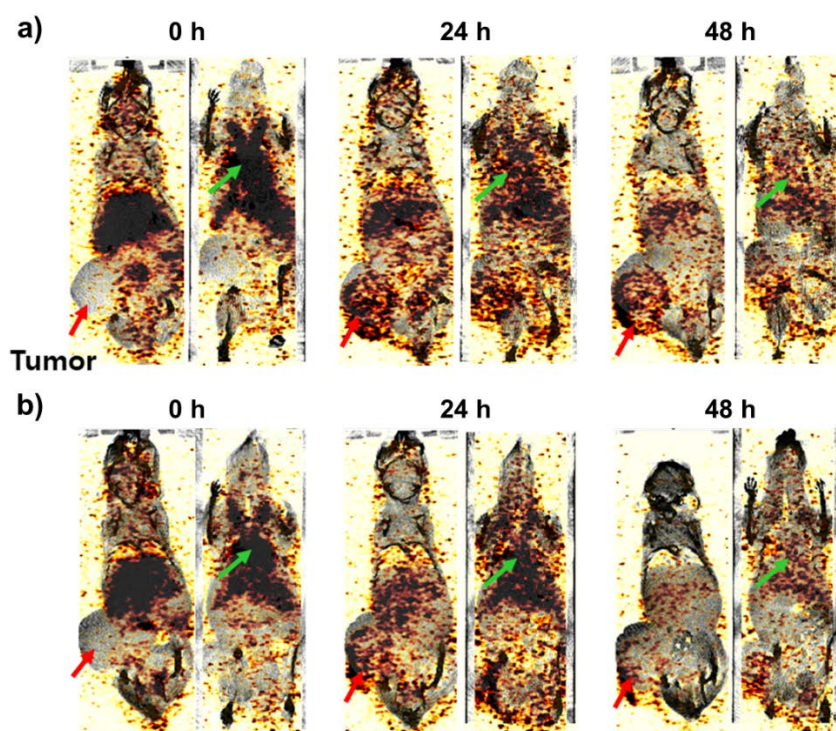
In vivo SPECT/CT imaging and quantitative analysis of ^{177}Lu -Ctx.
